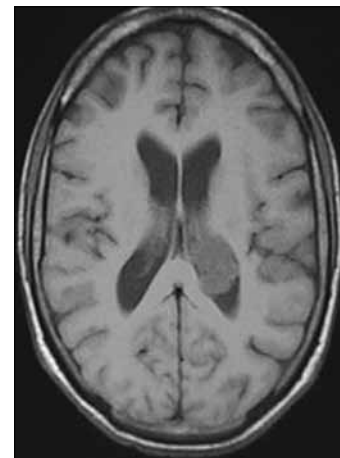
T1-weighted axial magnetic resonance imaging scan of the patient showing a mass in the body and atrium of the left lateral ventricle which is hypointense compared to the normal white matter
